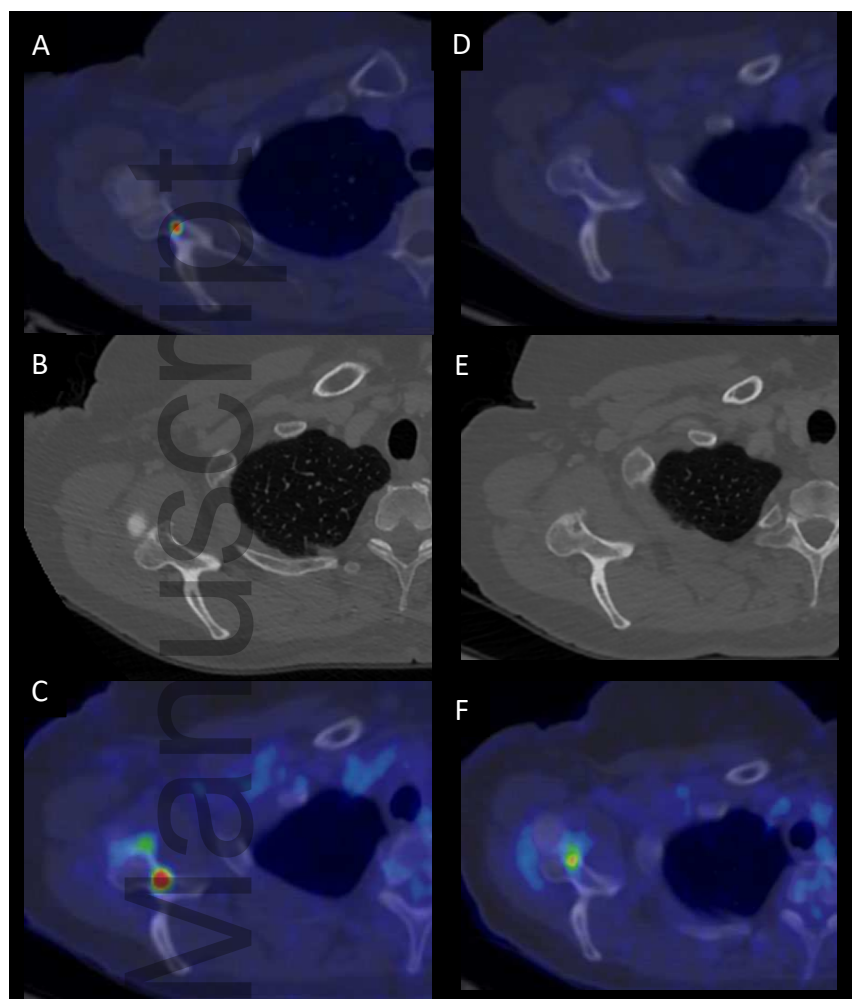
18F-FES PET, diagnostic CT and FDG-PET images of the right scapular lesion initially (A,B and C), and during restaging 4 months later (D, E and F).
